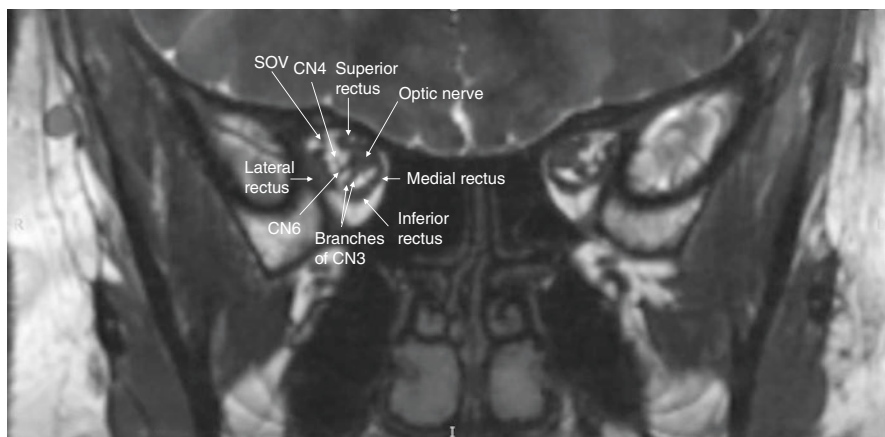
Orbital apex. Coronal CISS MRI shows the structures of the orbital apex. CNs III, IV, V1, and VI enter the orbit through the superior orbital fissure (CNs III, nasociliary branch of V1 and VI within the annulus of Zinn, and CN IV and lacrimal and frontal branches of V1 outside the bounds of the annulus). (© AR Carey 2020. All Rights Reserved)
